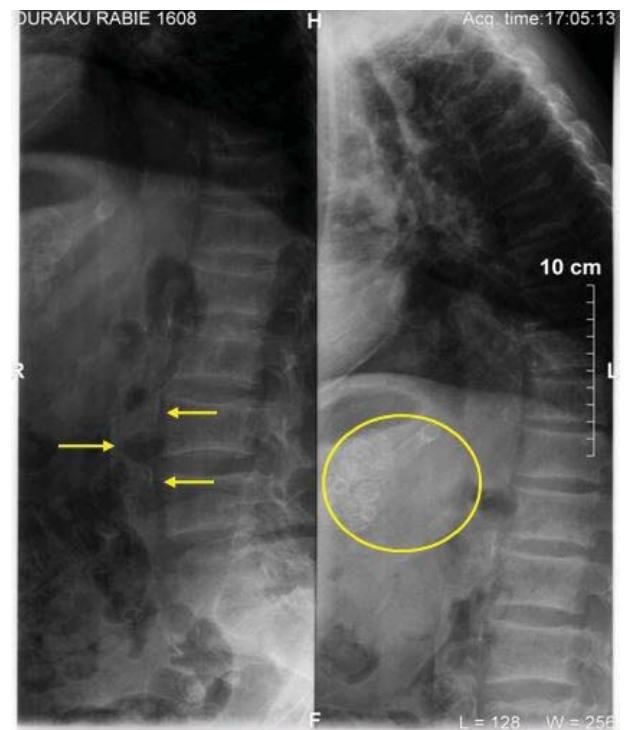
Lateral lumbar plan X-ray. Arrows indicate calcification of abdominal aort and circle shows calcification of the mesenteric artery.
